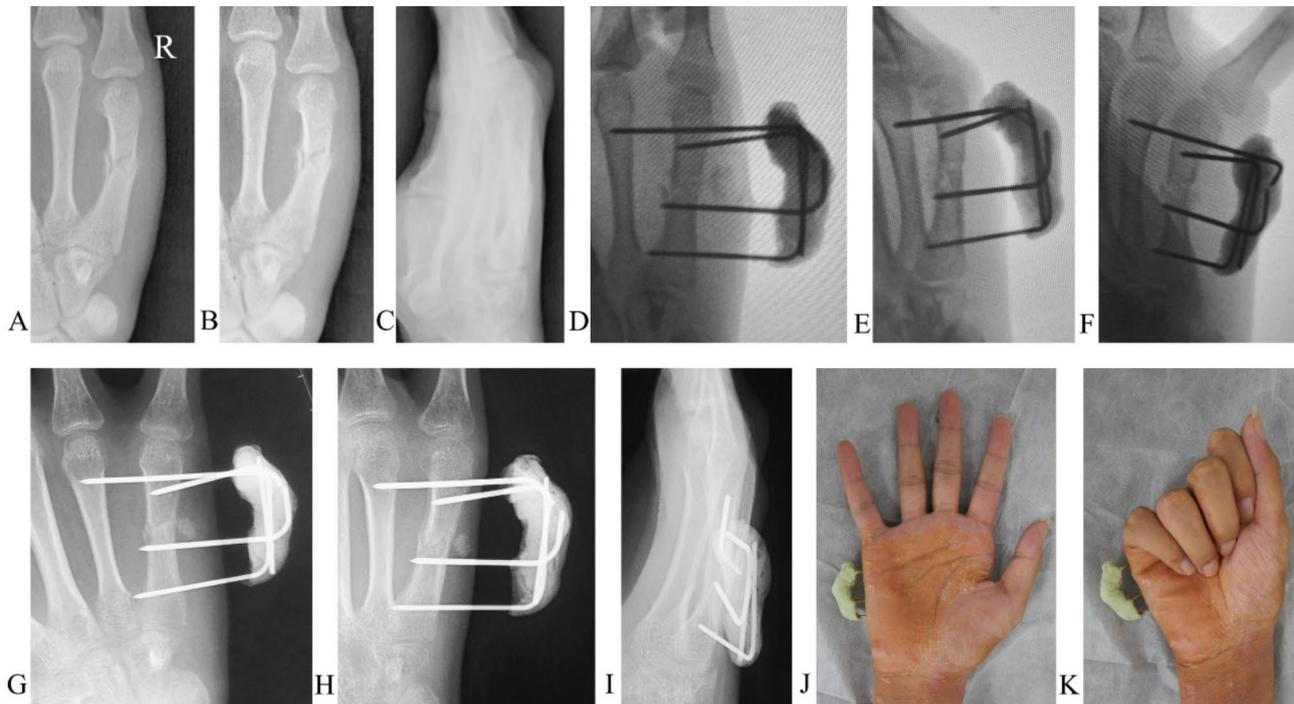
A malunion of the fifth metacarpal shaft fracture. A. A PA X-ray. B. An oblique X-ray. C. A lateral X-ray. D. A PA X-ray shows that osteotomy, fixation, and bone grafting are complete. E. An oblique X-ray. F. A reverse oblique X-ray. G. A PA X-ray shows bone healing after 4 weeks. H. An oblique X-ray. I. A lateral X-ray. J. Extension of the hand 4 weeks after surgery. K. Flexion
